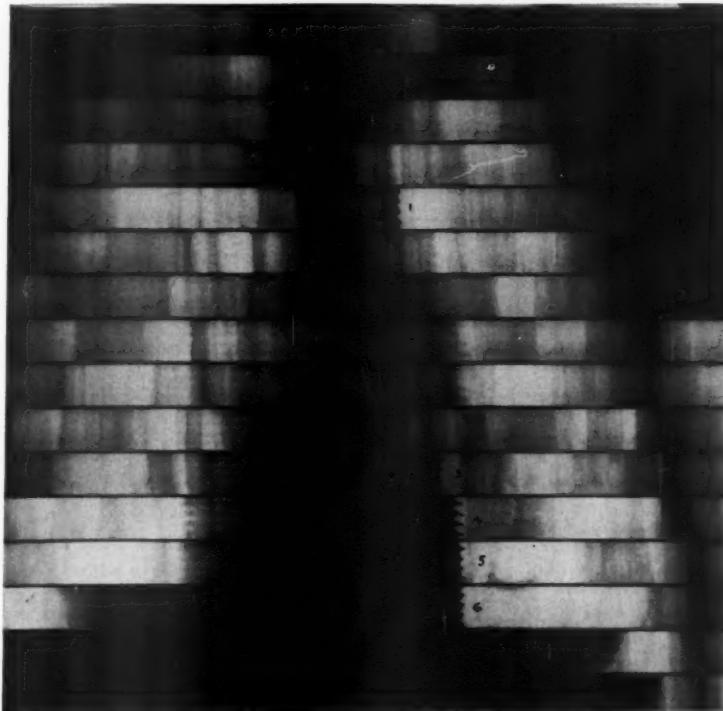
Left oblique roentgenkymogram from a man 52 years old. Coronary artery occlusion six weeks previously. Partial systolic expansion (stepladder effect) in interval four; lateral movement in midsystole in interval five.
